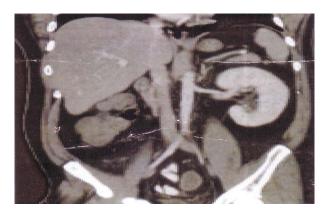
CT Scan-unilateral agenesis of kidney in MRKH syndrome type-II $\,$
